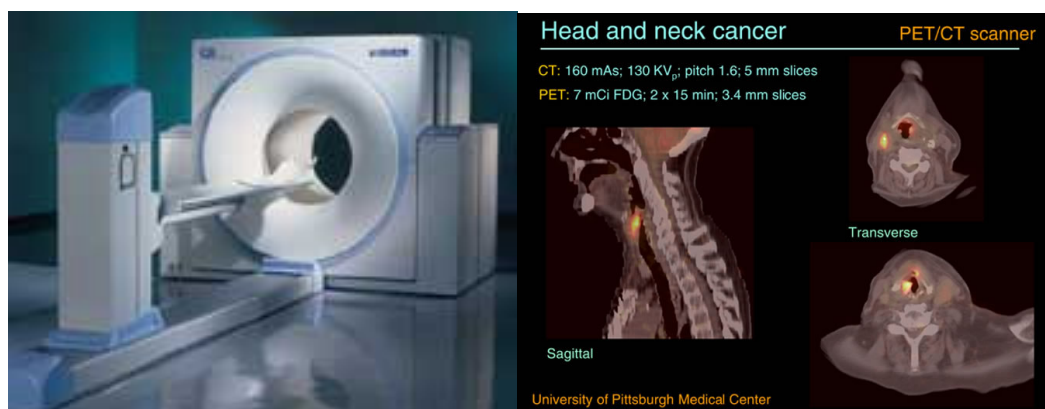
PET-CT in a nuclear medicine department and morphological-functional images
